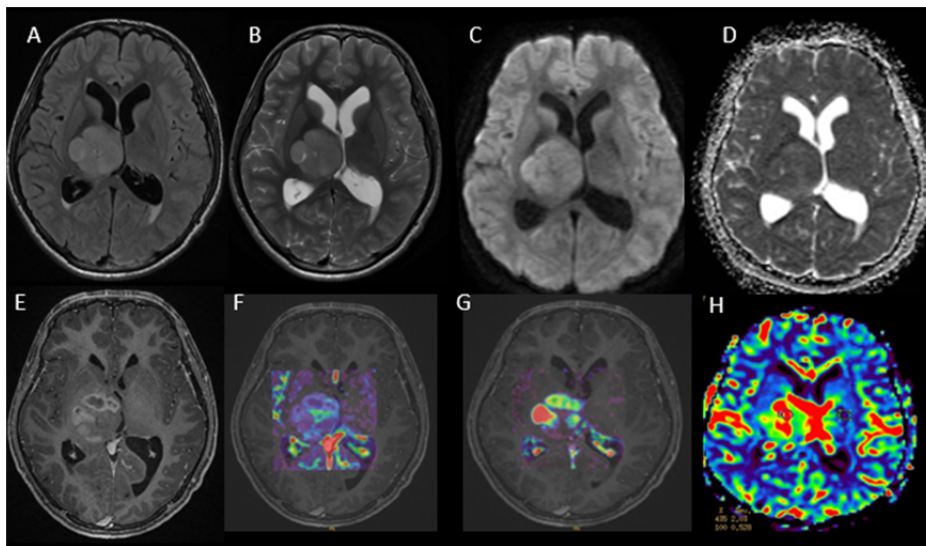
FLAIR (A) and T2WI (B) demonstrate the well circumscribed intra-axial mass lesion epicentred in the right thalamic region. No areas of diffusion restriction noted in the lesion(C,D). The lesion shows areas of peripheral enhancement with few central non enhancing areas within (E) , high values of k-trans (F) , Ve (G) and rCBV (H) on MR perfusion.
